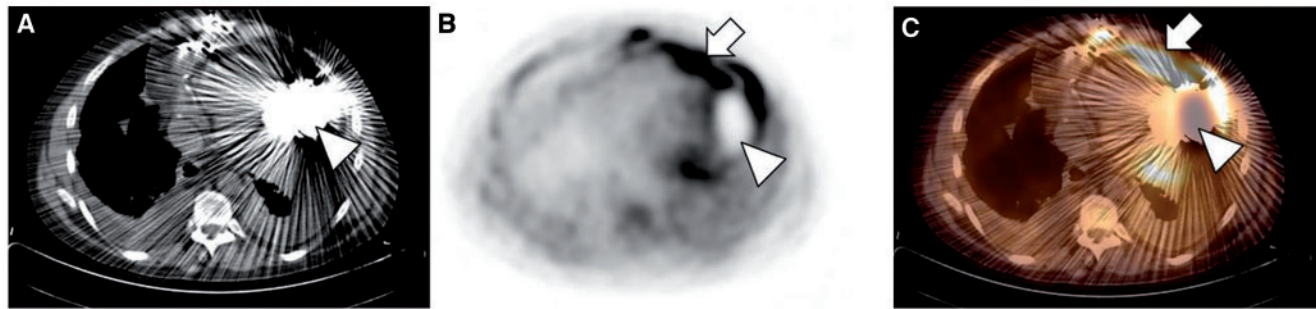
Example of a positive <sup>18</sup>F-FDG PET/CT scan in a patient with 2 HeartWare HVAD devices (BiVAD) and a VAD specific pump infection. Axial CT image (A) shows the LVAD (arrow head) with significant metal artifacts. The corresponding PET image (B) and the fused PET/CT image (C) show a photopenic area in the position of the LVAD and an abnormal elevated <sup>18</sup>F-FDG uptake in the surrounding infected tissue (arrow). LVAD: left ventricular assist devices; VAD: ventricular assist device.
